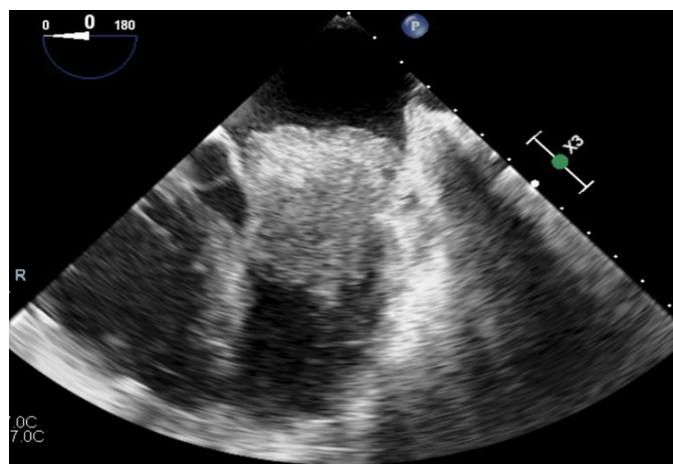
Large left atrial mass moving into the left ventricle across the mitral valve observed on a pre-op echocardiography.
